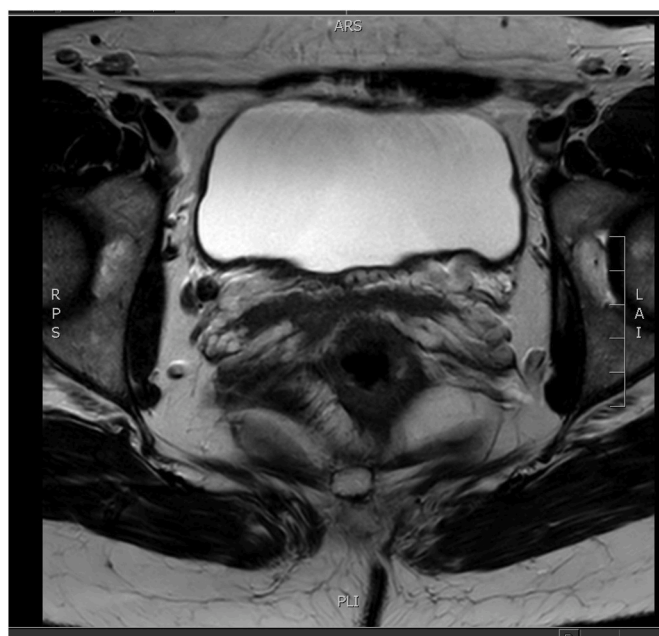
MRI demonstrating complete resection of previous tumour with no deeper invasion present.
